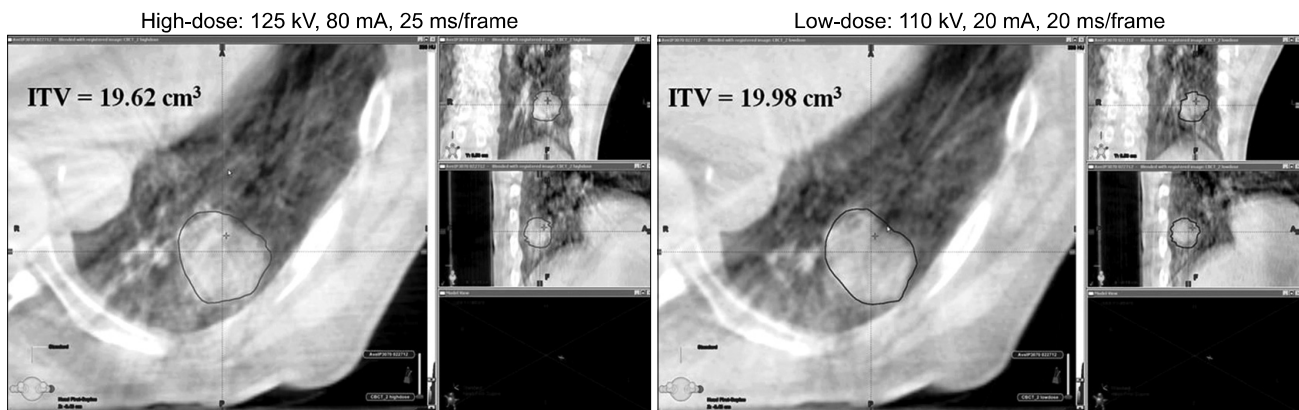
“HD_LD Contour Comparison”. A representative, example patient case imaged with both the LIDM and HIDM FBCBCTs. An expert Radiation Oncologist contoured the visible ITVs on each image.
